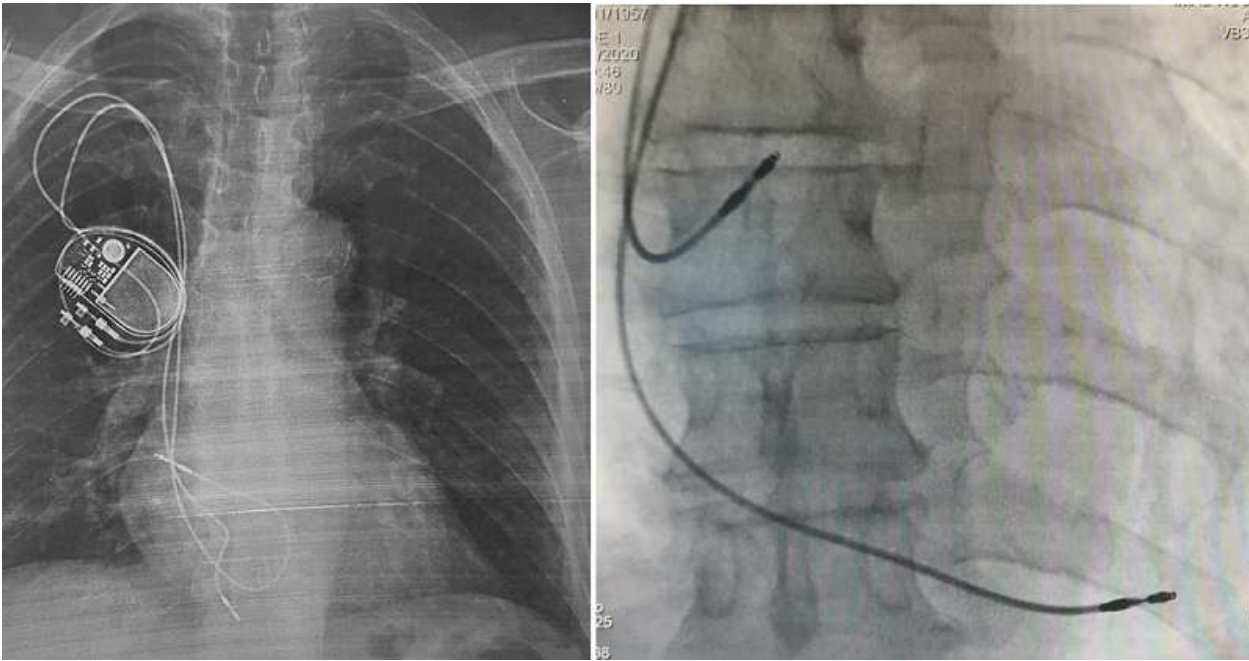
(A) chest X-RAY showing the two leads in the right atrium; (B) image after lead's replacement
